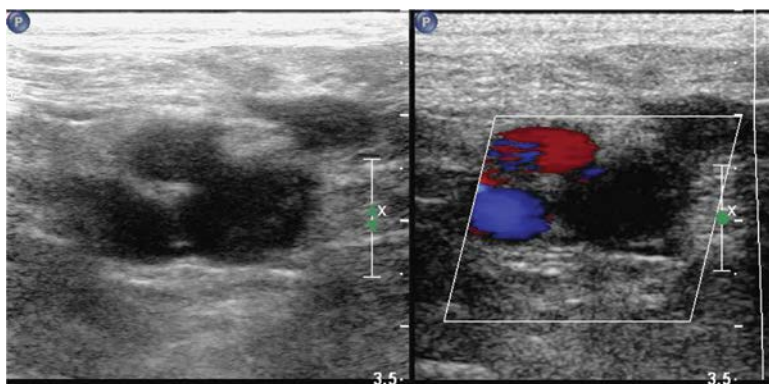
Doppler ultrasound scan showing a deep vein thrombosis.
